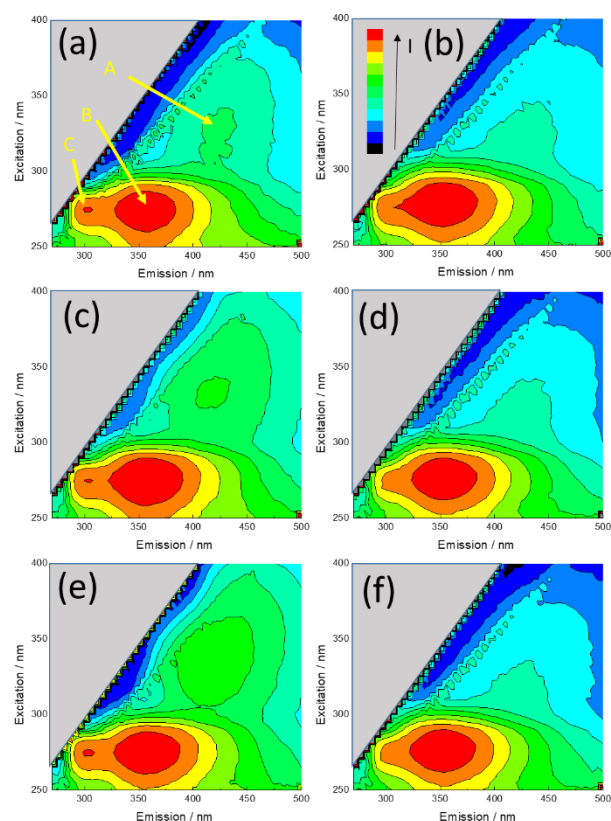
EEMs for (a) raw, (b) raw digested, (c) thermal, (d) thermal digested, (e) ultrasound and (f) ultrasound digested apple juice. The increasing intensity scale (blue to red, indicated in (b)) is logarithmic to clarify lower intensity emissions.
